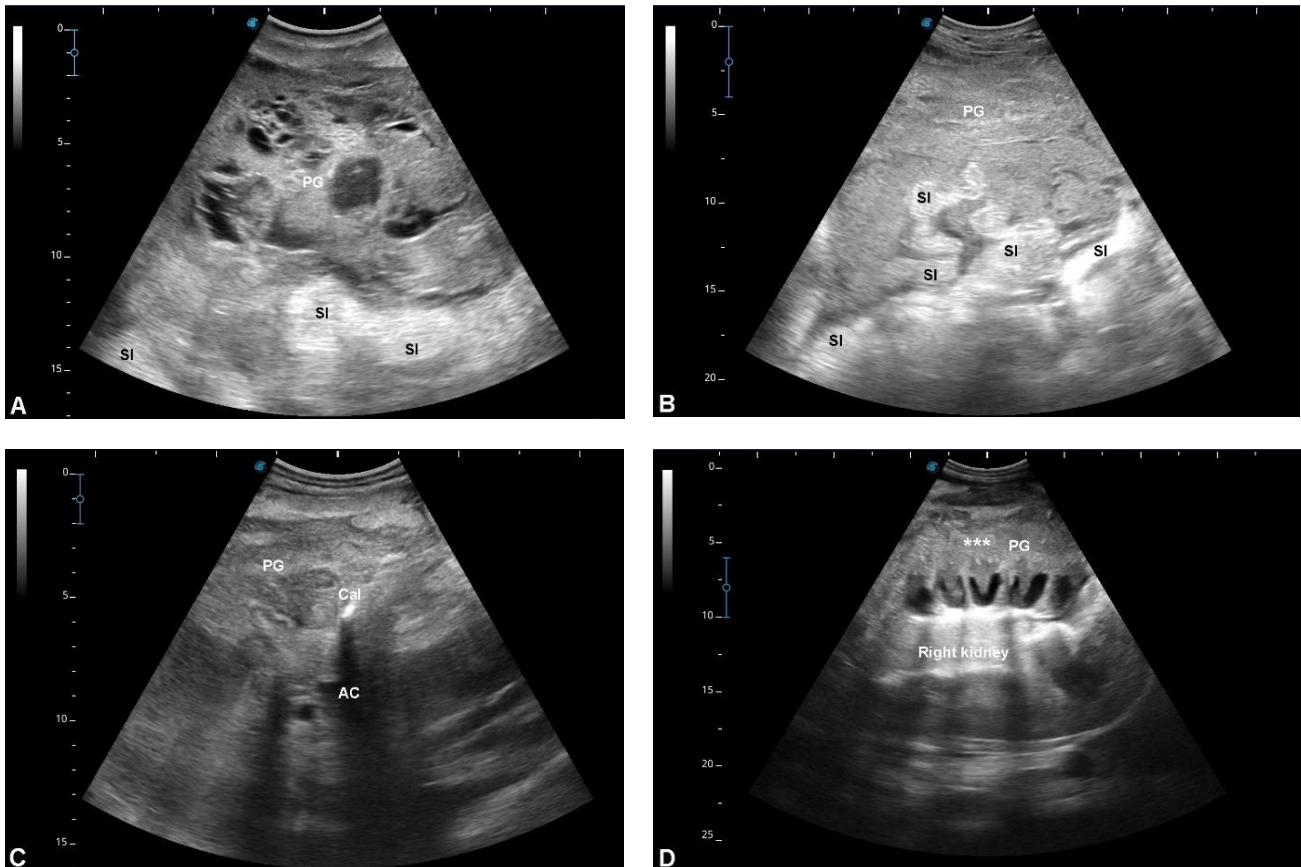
Ultrasonographic findings in a 6-year-old female dromedary camel with disseminated pyogranulomas (PG). A large area of heterogenous echogenicity between the small intestinal loops (SI) on the right abdomen were imaged; some parts are anechoic (A). Other areas were homogenously isoechoic compared to echogenic intestines (B). Spots of calcification (Cal) with distal acoustic shadowing (AC) were imaged within the lesions (C). Similar areas of dissemination (*) were imaged withing the right renal parenchyma (D).
